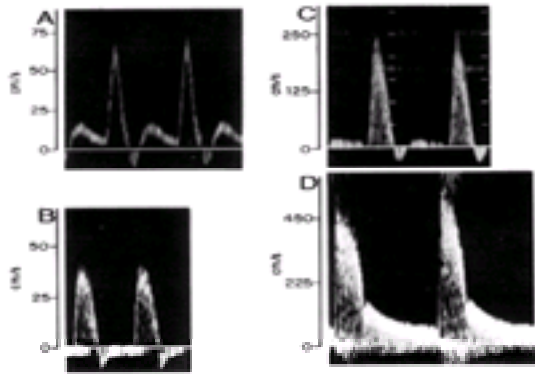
Spectral analysis of Doppler flow signals. (A) Normal; (B) 1 to 19 per cent diameter stenosis; (C) 20 to 50 per cent diameter stenosis; (D) greater than 50 per cent stenosis.
